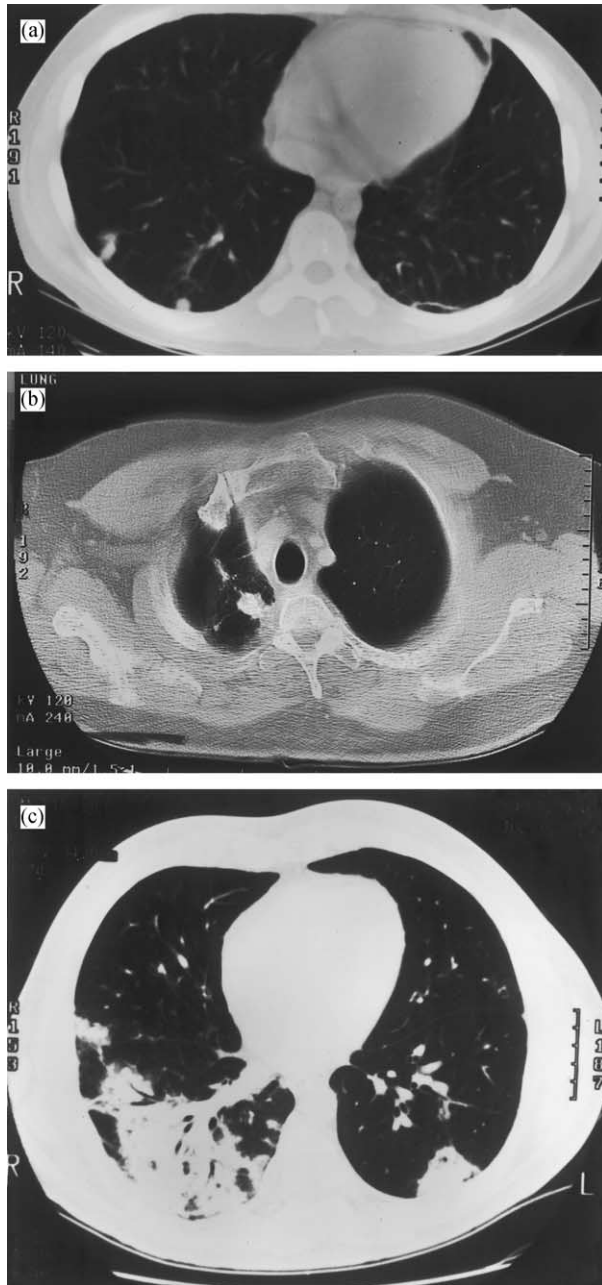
CT scans of the chest in three patients with malignancy and BOOP on open lung biopsy or resection. (a) A patient with testicular cancer and pulmonary nodules, (b) mass in the right upper lung field in a patient after lobectomy for NSCLCA and (c) nodular infiltrate in a patient with acute myelogenous leukemia during chemotherapy.
